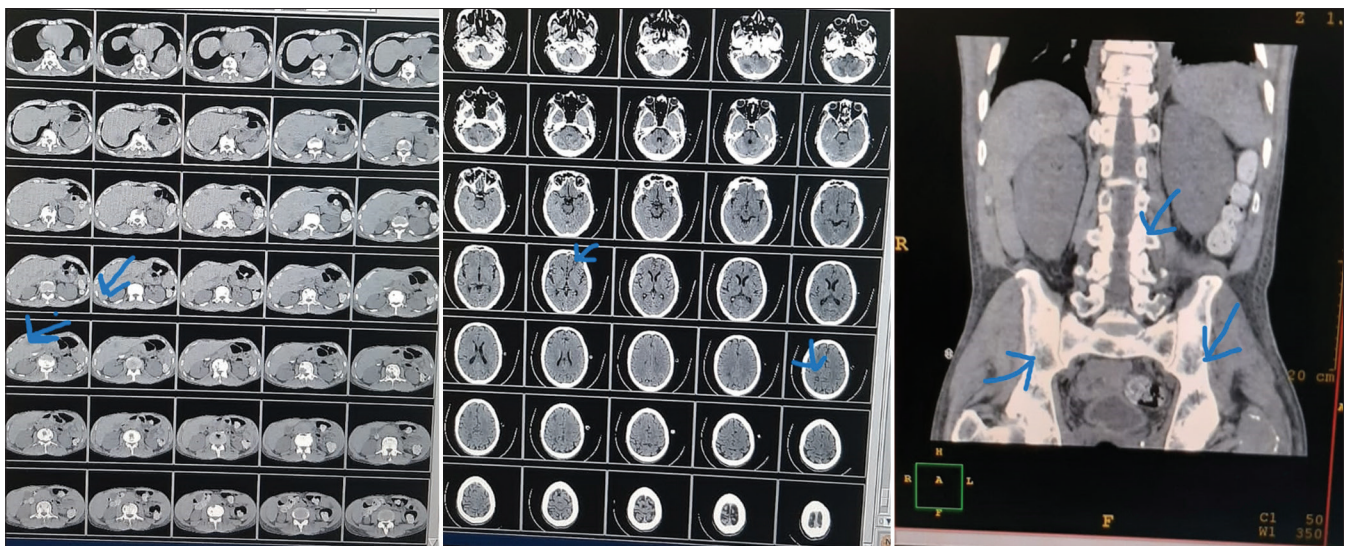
(a) Non-contrast CT abdomen: multiple hypodense lesions can be appreciated in the liver. (b) Non-contrast CT Head-two hyperdense lesions surrounded by edema seen in the cerebral cortex (c) Non-contrast CT abdomen sagittal plane shows moth-eaten appearance in the pelvic bones is visualised
